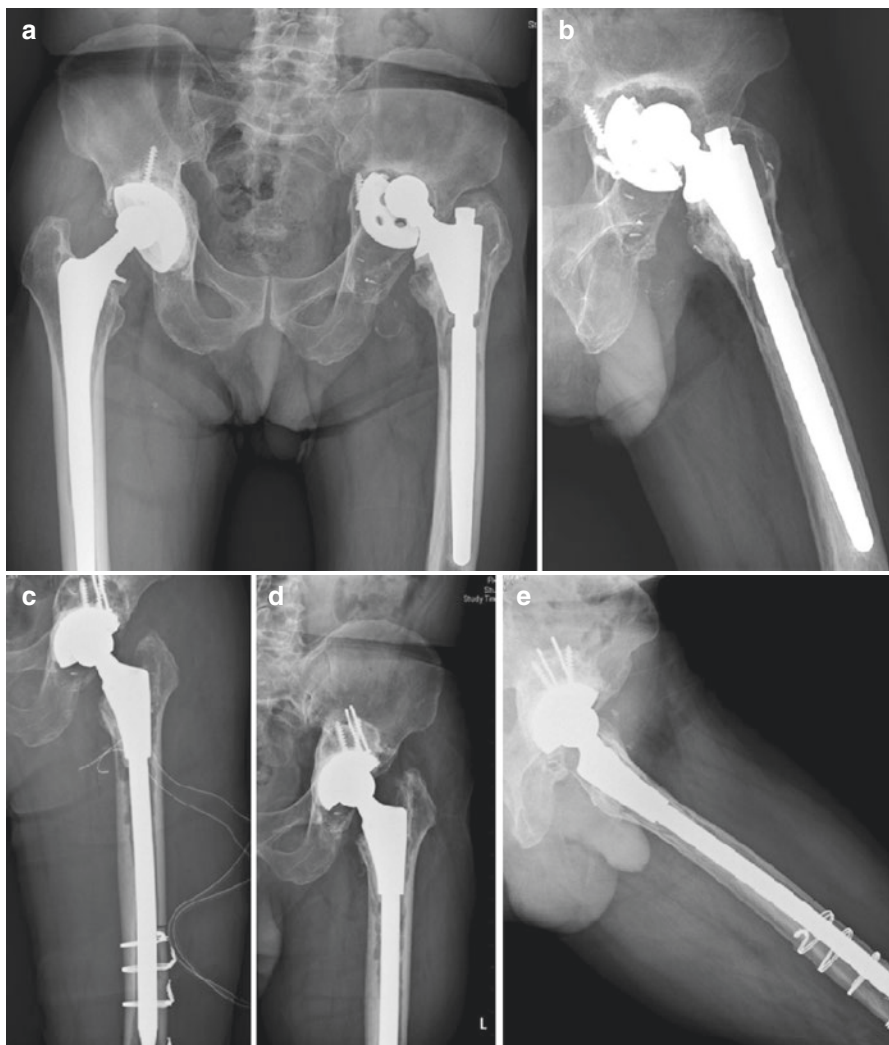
A 65-year-old man with failed left revision THA. Preoperative radiographs showed a Paprosky type IIIB defect of the acetabulum (a and b). Revision THA was performed using a structural femoral head allograft and cemented acetabular component with screw fixation; the stem was revised as well (c). Four years later, radiographs showed consolidation of the femoral head allograft without loosening of the cup and femoral revision (d and e) (these pictures were agreed by the patient for publication)
